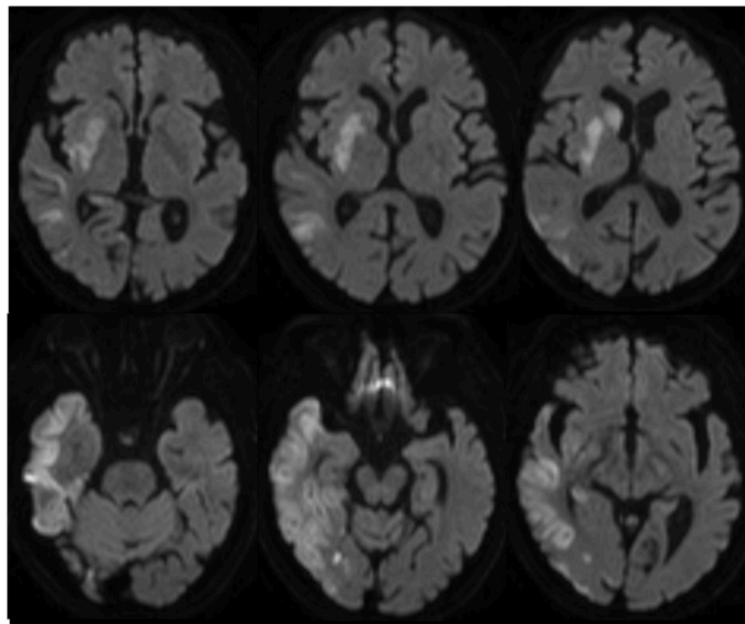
Stroke imaging of Mr. AB. Top: Angiography performed before (left) and after (right) endovascular thrombectomy. The white arrow highlights the arterial occlusion in the M1 segment of the right middle cerebral artery. Bottom: Diffusion-weighted MRI imaging performed 4 days after stroke. Hyperintensity indicates areas of brain infarct.
